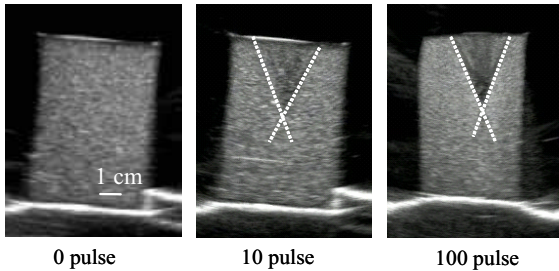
Ultrasound images of the gels after ultrasound irradiation showing the degree of bubble destruction for different pulse numbers.
